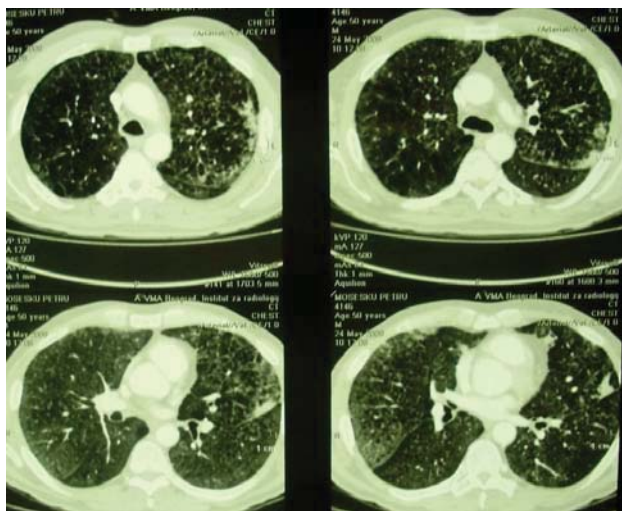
Multislice computed tomography scan of the chest reveals patchy ground-glass opacification with interlobular thickening bilaterally, without fibrotic changes
